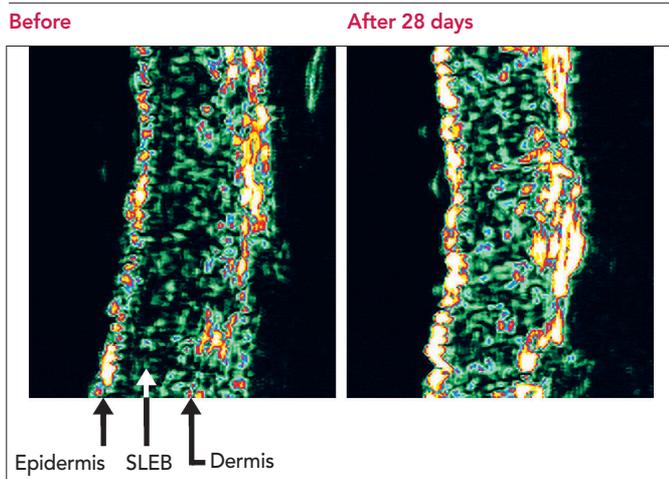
Representative ultrasound image of the increase in epidermis + dermis density after 28 days treatment with 0.4% goji stem cell active. SLEB = subepidermal low-echogenic band.
